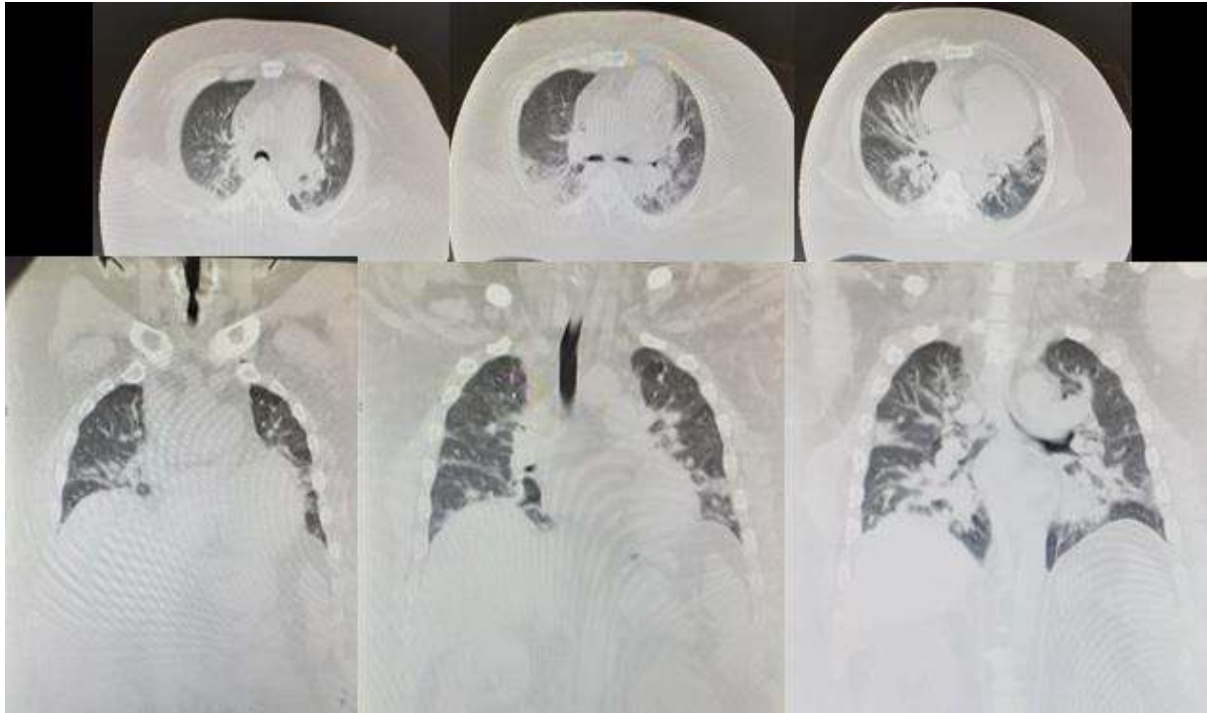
Chest CT-Scan: cardiomegaly with pulmonary vascular congestion, pulmonary edema and pneumonia
